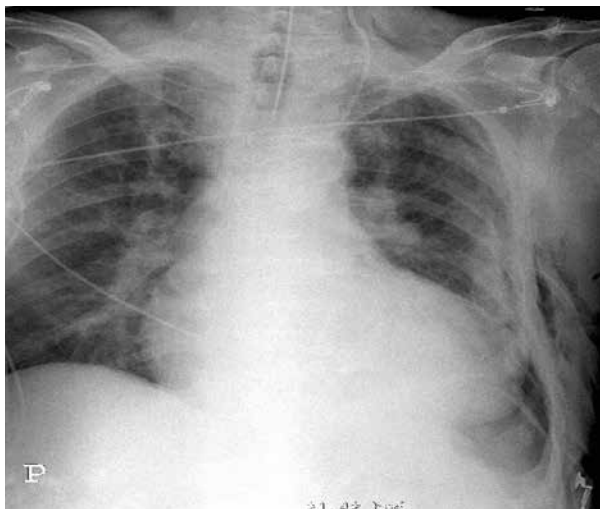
X-ray of the chest immediately after surgery; the source of bleeding was an injury to the intercostal artery
